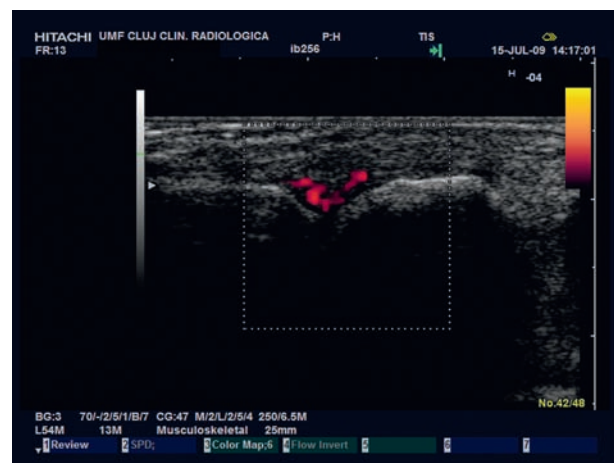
Power Doppler US: F, 45 years, proliferated synovial vascularity in the right second MCP joint, score 3
